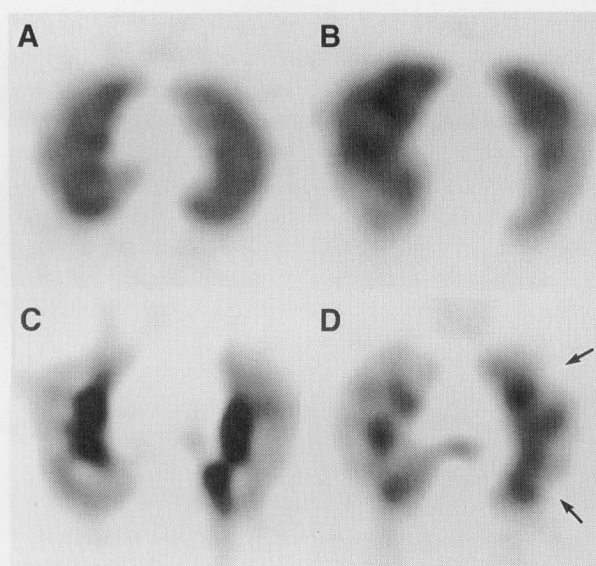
Scores of the Technegas findings in SPECT images. A: grade 1, B: grade 2, C: grade 3, D: grade 4. Note regional defects in the grade 4 (arrows).
